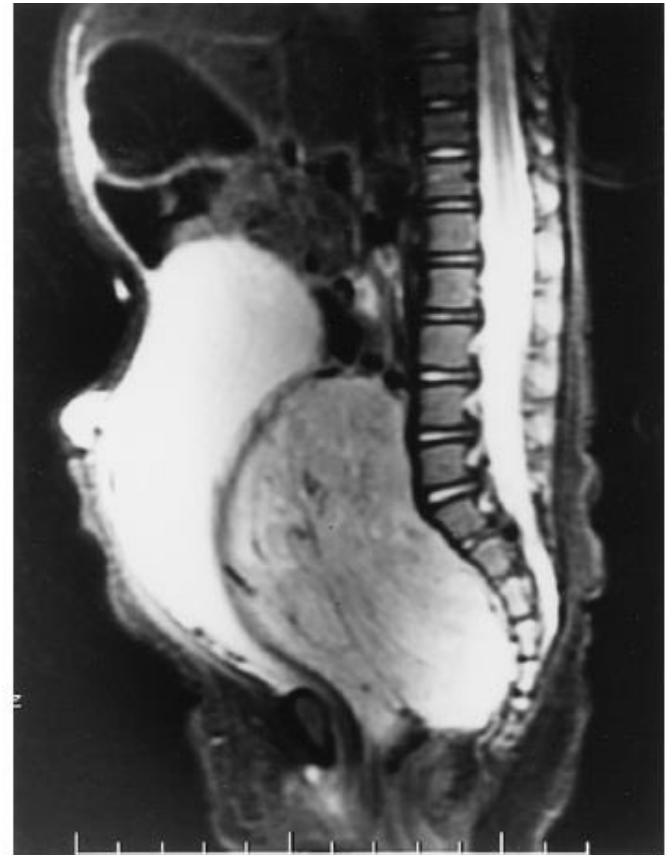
MRI demonstrating compression of bowel and bladder by a pelvic neuroblastoma.
